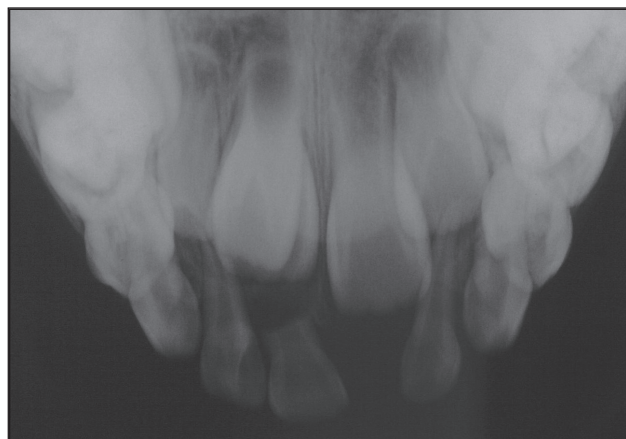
Case 3: An upper anterior occlusal radiograph shows a supernumerary tooth in the right incisor region.
